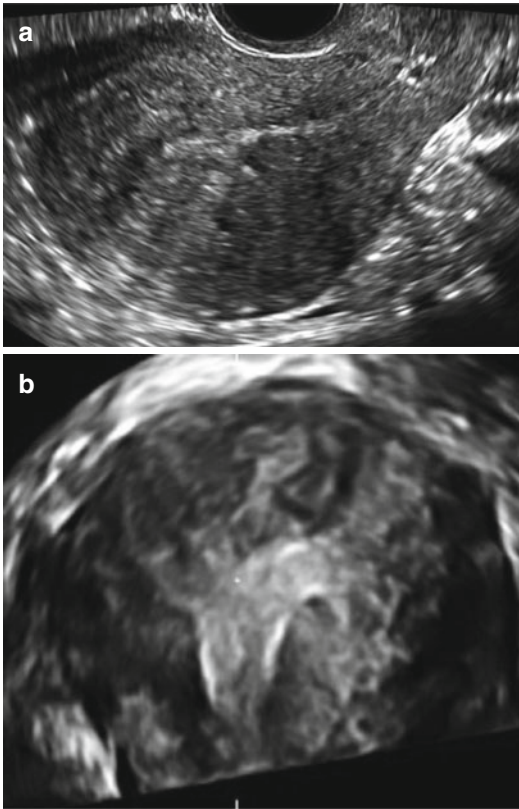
Ultrasound image of the uterus with adenomyosis. (a) Gray scale longitudinal section showed an asymmetrically thickened of the uterine wall and with diffuse inhomogeneous, irregular myometrial echotexture, and presence of small hyperechoic and cystic areas. (b) Coronal section of the same uterus, the junctional zone is irregular, ill defined and completely infiltrated by adenomyosis
